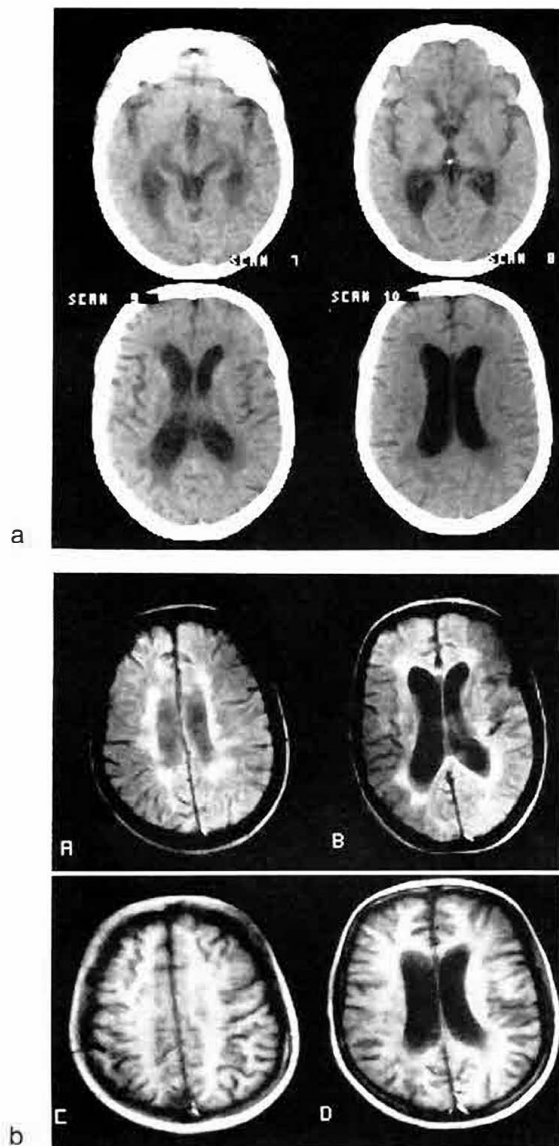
+ b: Comparable CT (1a) and NMR (1b) SE scans at ventricular level in a patient with multiple sclerosis. The two posterior lesions and the two anterior periventricular lesions seen on CT scan are also evident on the NMR scan. NMR scan shows additional multiple lesions which line the lateral walls of the ventricles (1bA).  $T_R = 400$ ,  $T_I = 30/60$  msec.
